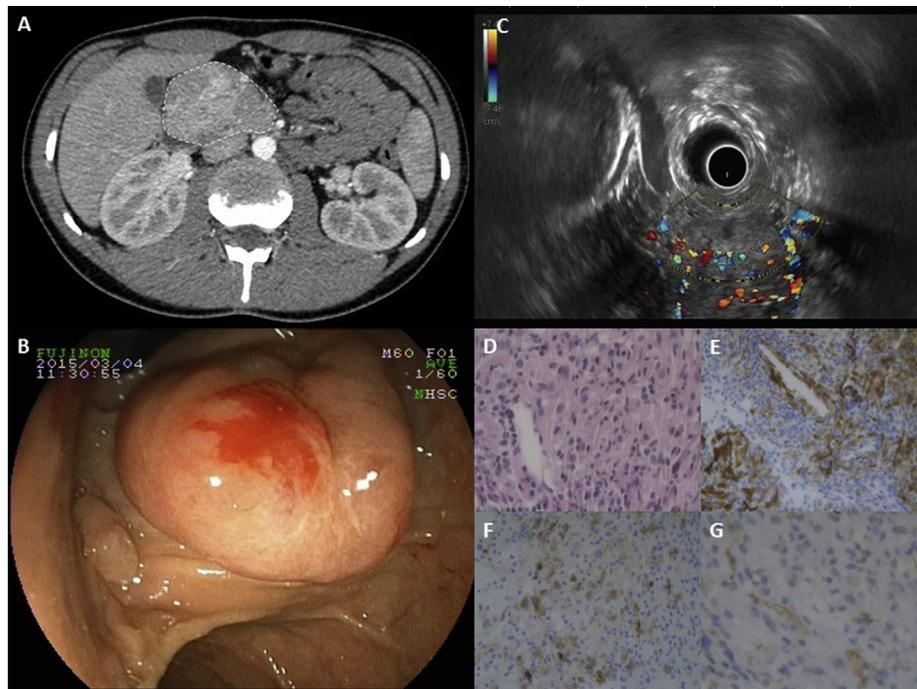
PECOma: initial exams A) Abdominal CT: hypervascular tumor of 55 cm in the head of the pancreas with central necrosis and invasion of duodenal wall without bile or pancreatic duct compression. B) Duodenoscopy: bleeding duodeno-pancreatic mass, apart from the papilla. C) EUS: hypervascular mass of the head of the pancreas. D) Epithelioid cells with clear or focally granular eosinophilic cytoplasm, with oval nuclei. E) Melan A+ cells, F) HMB45 + cells, G) smooth muscle actine + cells.
